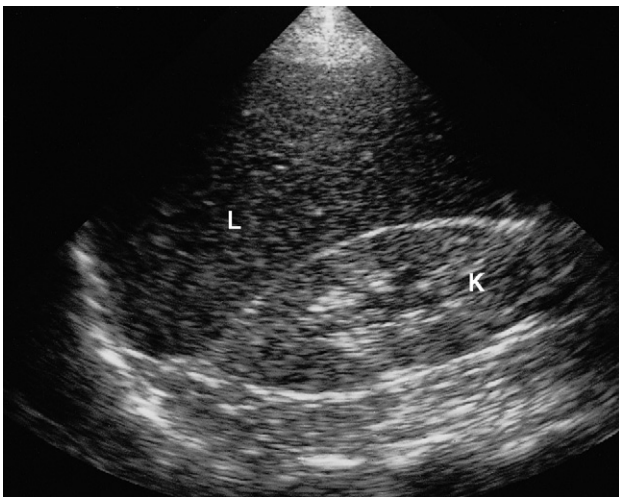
Intrinsic renal disease. Ultrasound of right kidney (longitudinal scan). The kidney is small and the cortical echoes are increased and therefore the central echo is less obvious. Normally, the liver is more echo-reflective than the renal cortex. K, kidney; L, liver.
